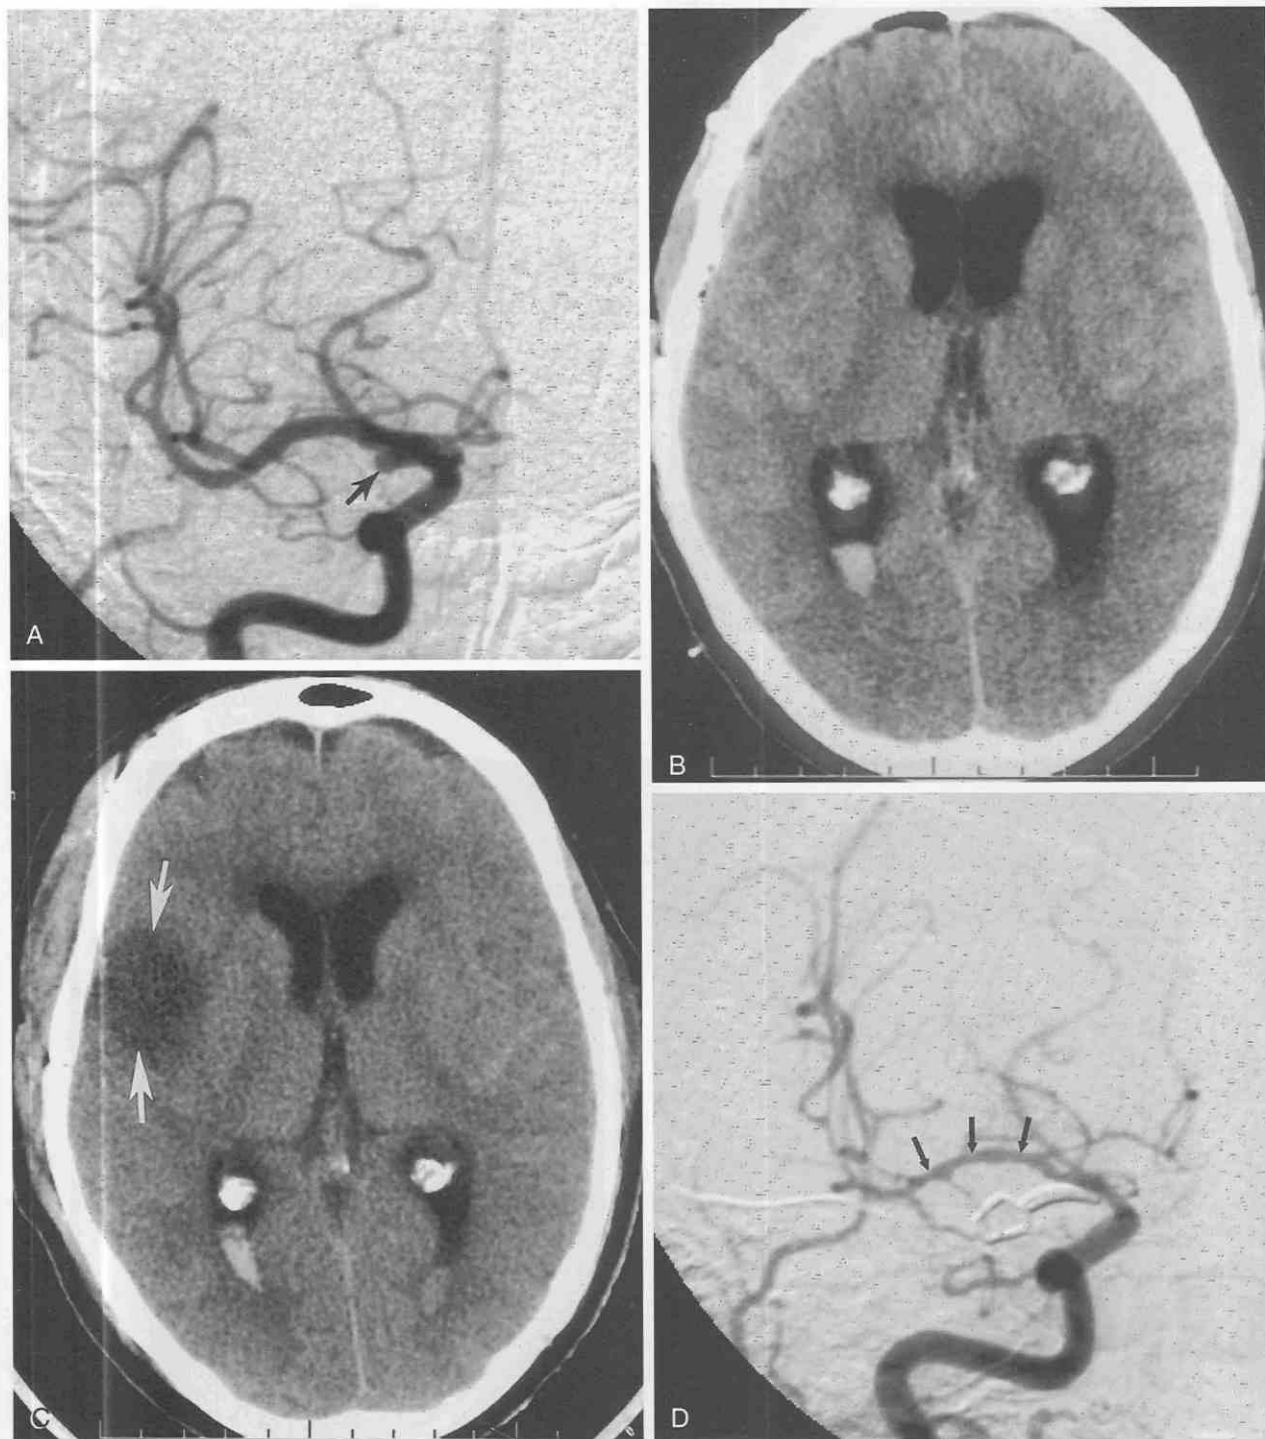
Ischemia caused by vasospasm. A, Digital subtraction catheter angiogram in a patient with subarachnoid hemorrhage. A ruptured posterior communicating artery-internal carotid artery junction aneurysm is seen (*arrow*). B, Unenhanced axial CT image immediately following ligation of the aneurysm shows postoperative changes but no evidence of infarction. C, Unenhanced CT 3 days later, after the onset of left-sided weakness, shows new focal hypodensity (*arrows*). D, A subsequent angiogram shows significant vasospasm in the right M1 segment (*small arrows*).
